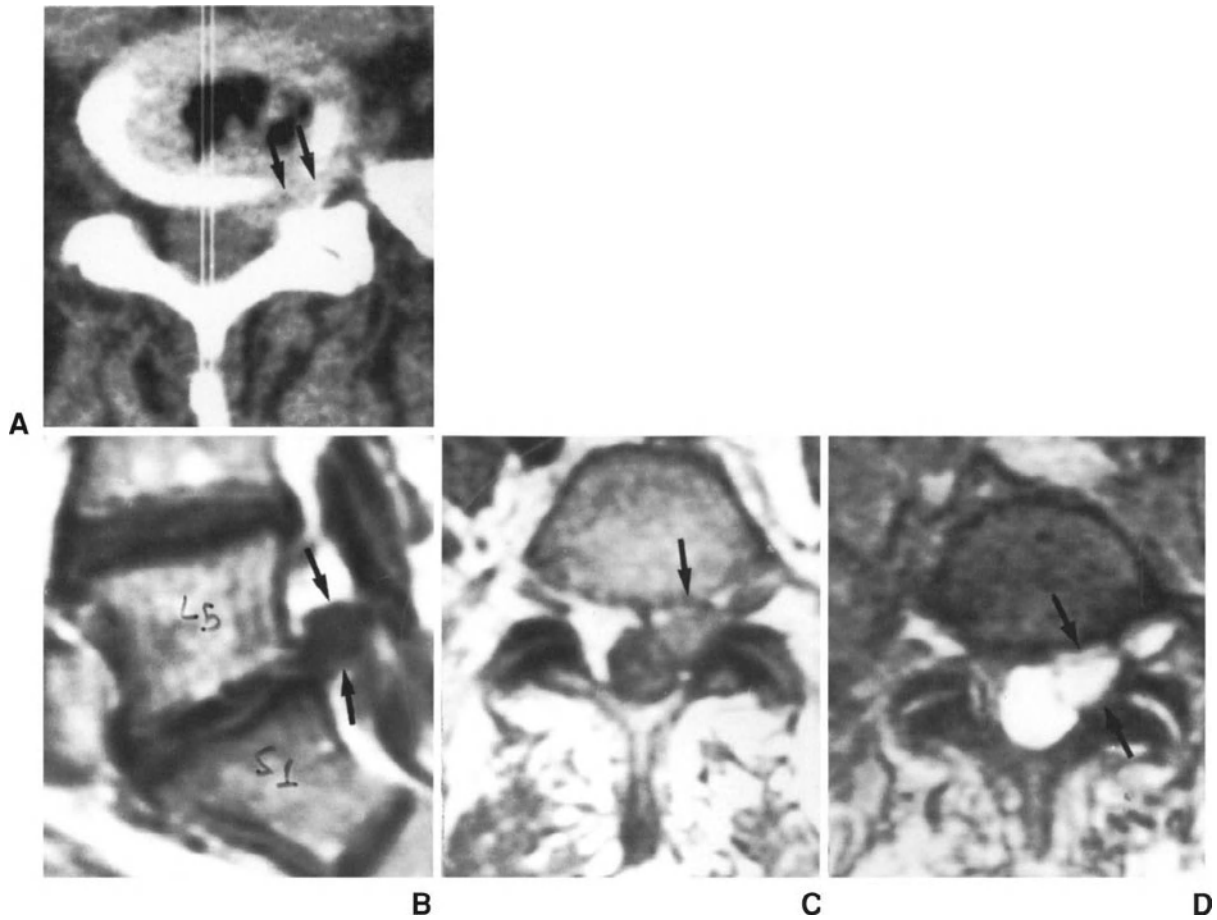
CT and MRI scans of a patient with recurrent herniation. (A) Preoperative axial CT scan at L5-S1 level revealing a left disc herniation located, in part, posterolaterally and, in part, within the neuroforamen (arrows). (B) Sagittal MR image obtained 20 months after primary discectomy, showing a large recurrent herniation (arrows) at L5-S1 level. (C) and (D) Axial MR images showing the disc fragment extruded cranially (arrows); the recurrence appears to be larger than primary herniation.
